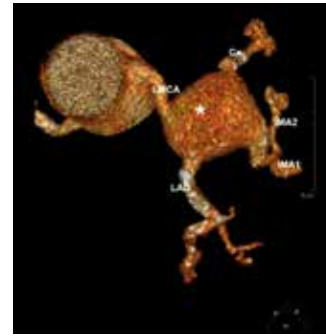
CT coronary angiography imaging of left coronary system after 3D reconstruction and subtraction of adjacent tissues. Aneurysm (*), Circumflex artery, Cx; Intermediate artery, IMA; Left anterior descending artery, LAD; Left main coronary artery, LMCA.
